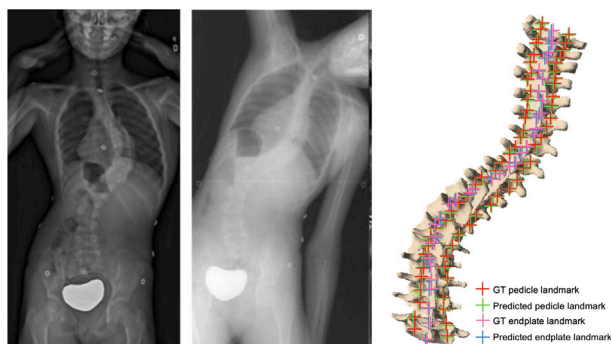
Upright and sagittal side X-ray images used for the prediction of a 3D spine model in the bending position.
